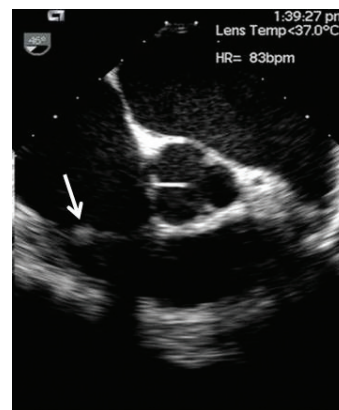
Transesophageal feature of the papillary fibroelastoma on the anterior leaflet of the tricuspid valve (arrow).
